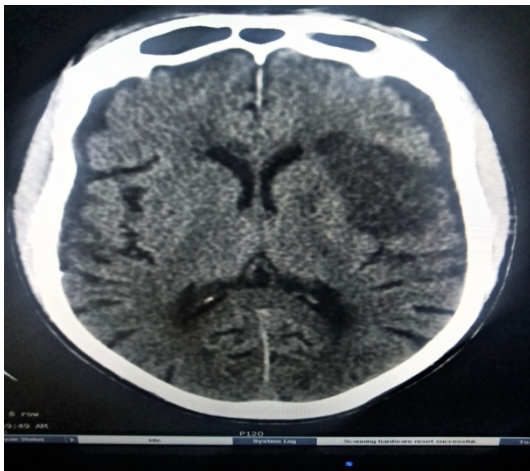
An axial CT Brain image demonstrating cerebral infarct
